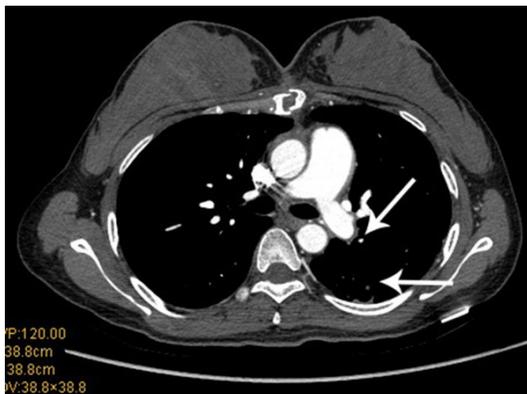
Enhanced chest CT at 1 month after surgery: absence of thrombus in left pulmonary artery, with consolidation and atelectasis in left lower lung almost completely absorbed (arrows indicate the original lesions).
